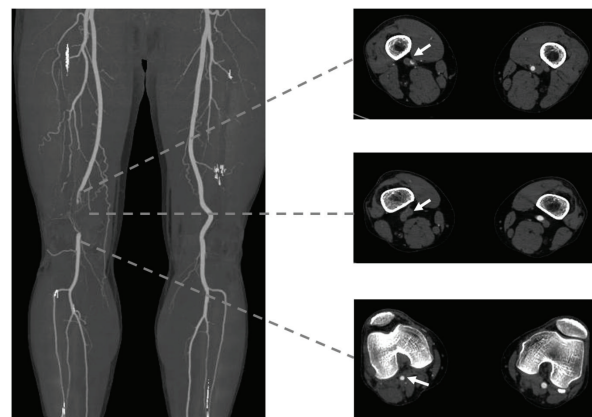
Lower extremity with computed tomography. White arrows indicate the right femoropopliteal artery with total occlusion in the P2 segment.
